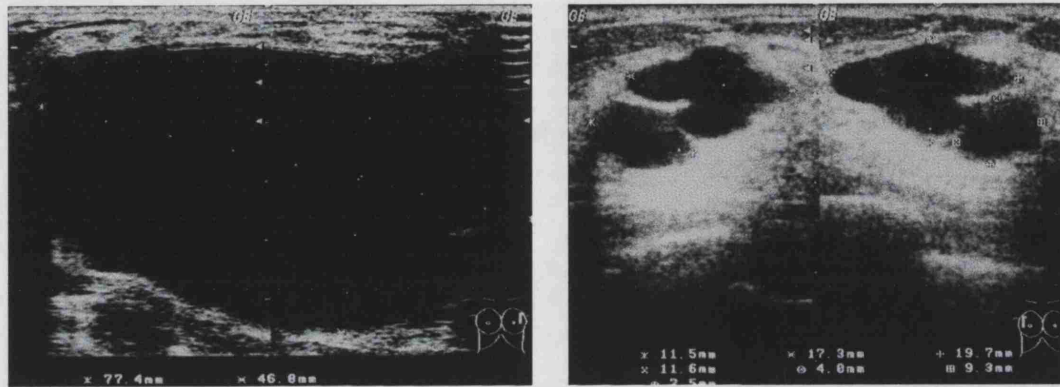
The ultrasound images of the a) left and b) right breasts of a patient with a large cyst in the left breast and small cysts in the right breast.
